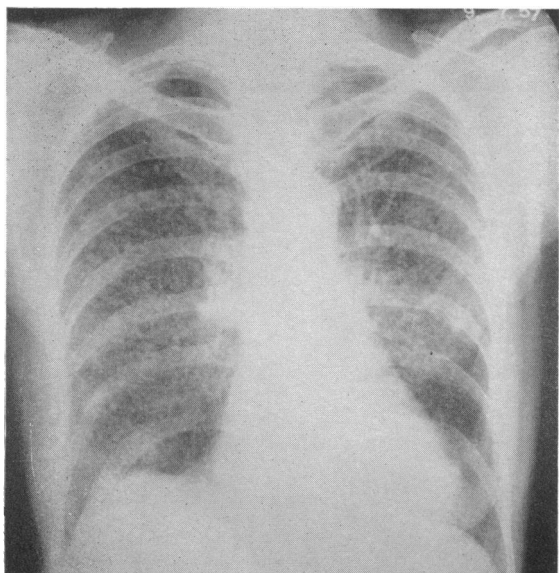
Case 6. Radiograph of chest, July 9, 1957.
